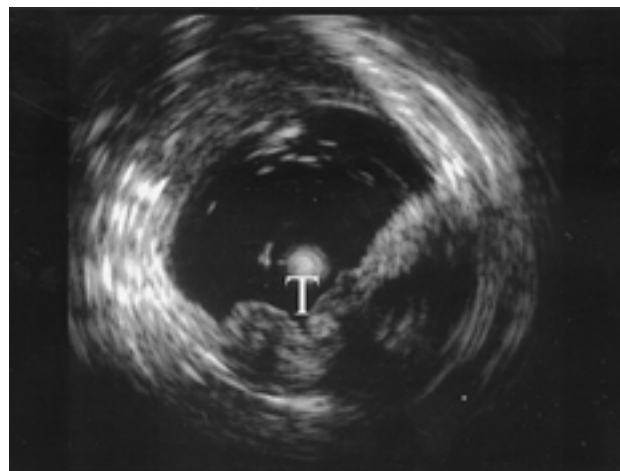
The UMP image of Case 2. The depth of invasion of the tumor (T) cannot be diagnosed due to ultrasound attenuation.
